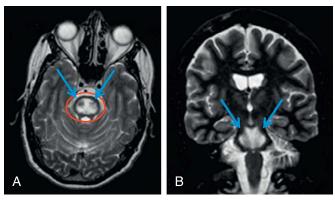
Central pontine myelinolysis—axial and coronal T2-weighted images show T2 hyperintense signal involving the central pons with peripheral pontine sparing *(red circle)* and sparing of the corticospinal tracts *(blue arrows)*. This pattern of involvement results in a T2 "bat wing" or "trident" appearance on axial imaging.
